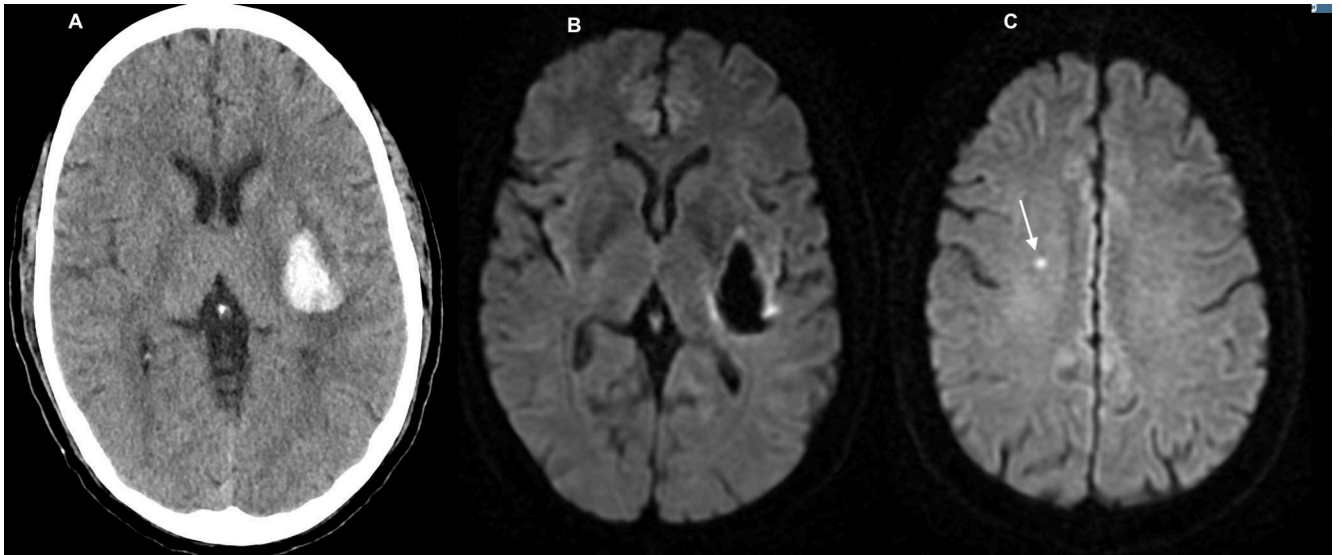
Diffusion-Weighted Imaging (DWI) Lesion after Intracerebral Hemorrhage. Computed Tomography Scan (Panel A) and Magnetic Resonance Imaging Scans of the Hematoma (Panel B) and DWI lesion (Panel C).
